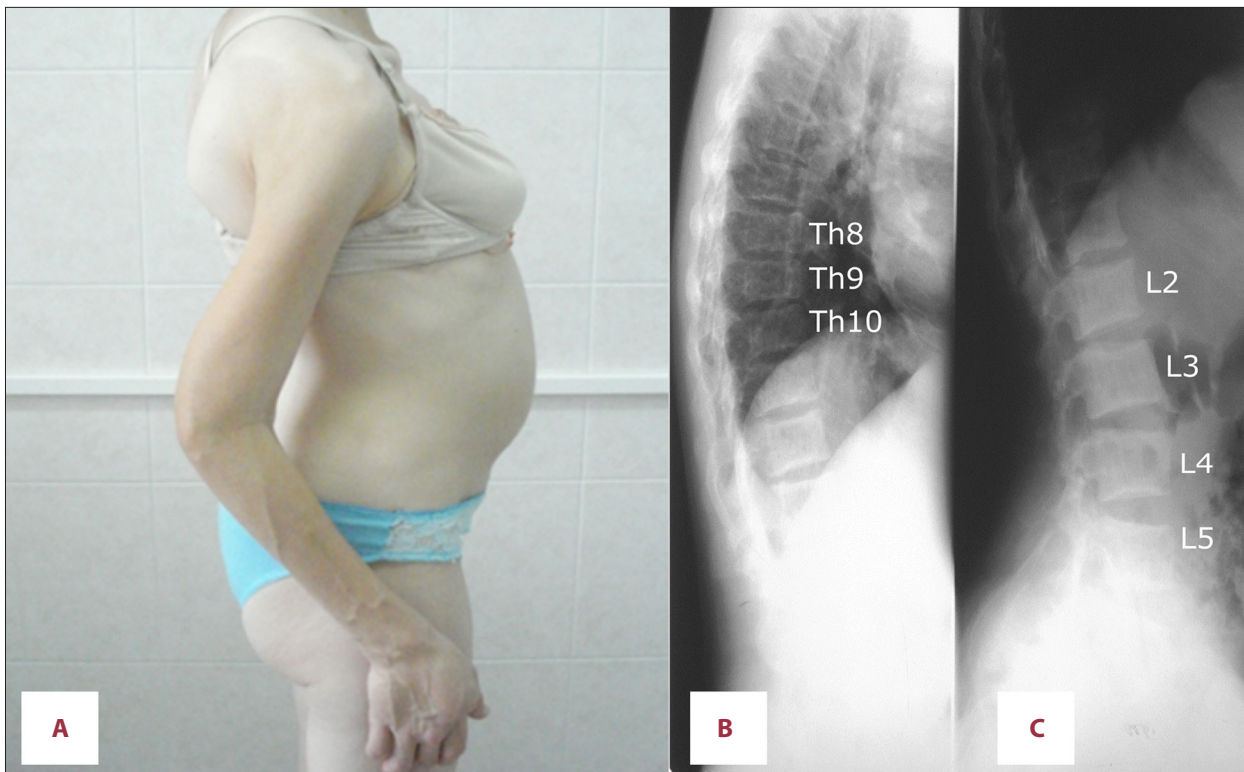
A case of pregnancy complicated by primary hyperparathyroidism: Macroscopic and X-ray images of the vertebrae. (A) The appearance of the 28-year-old woman before surgery showing the thoracic and lumbar spine deformity. (B) X-ray image of vertebral compression of T8–T10 and L2–L4. (C) X-ray image of vertebral compression of L5.
